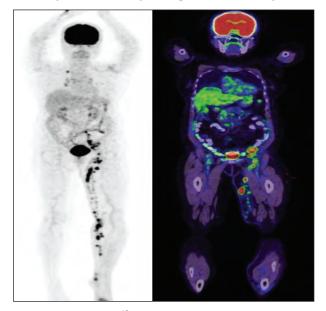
Whole body ¹⁸F-FDGPET-CT images of Maximum Intensity Projection (MIP) view (left) and coronal view (right) showing hypermetabolic nodules in left lower limb.
